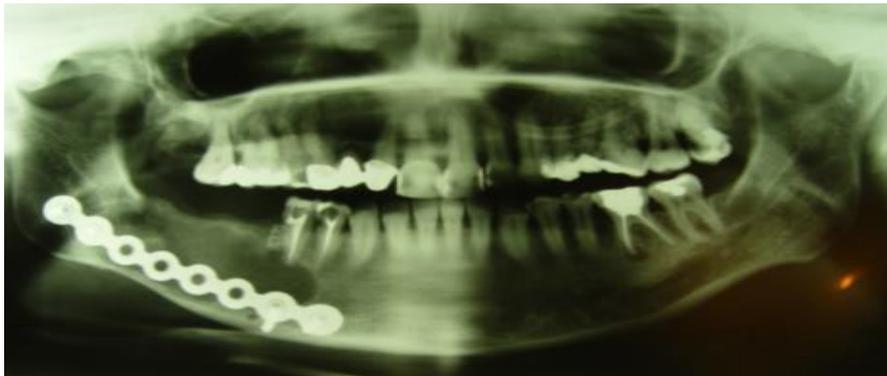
b.- Panoramic X-ray where we can see the plates after surgery.
